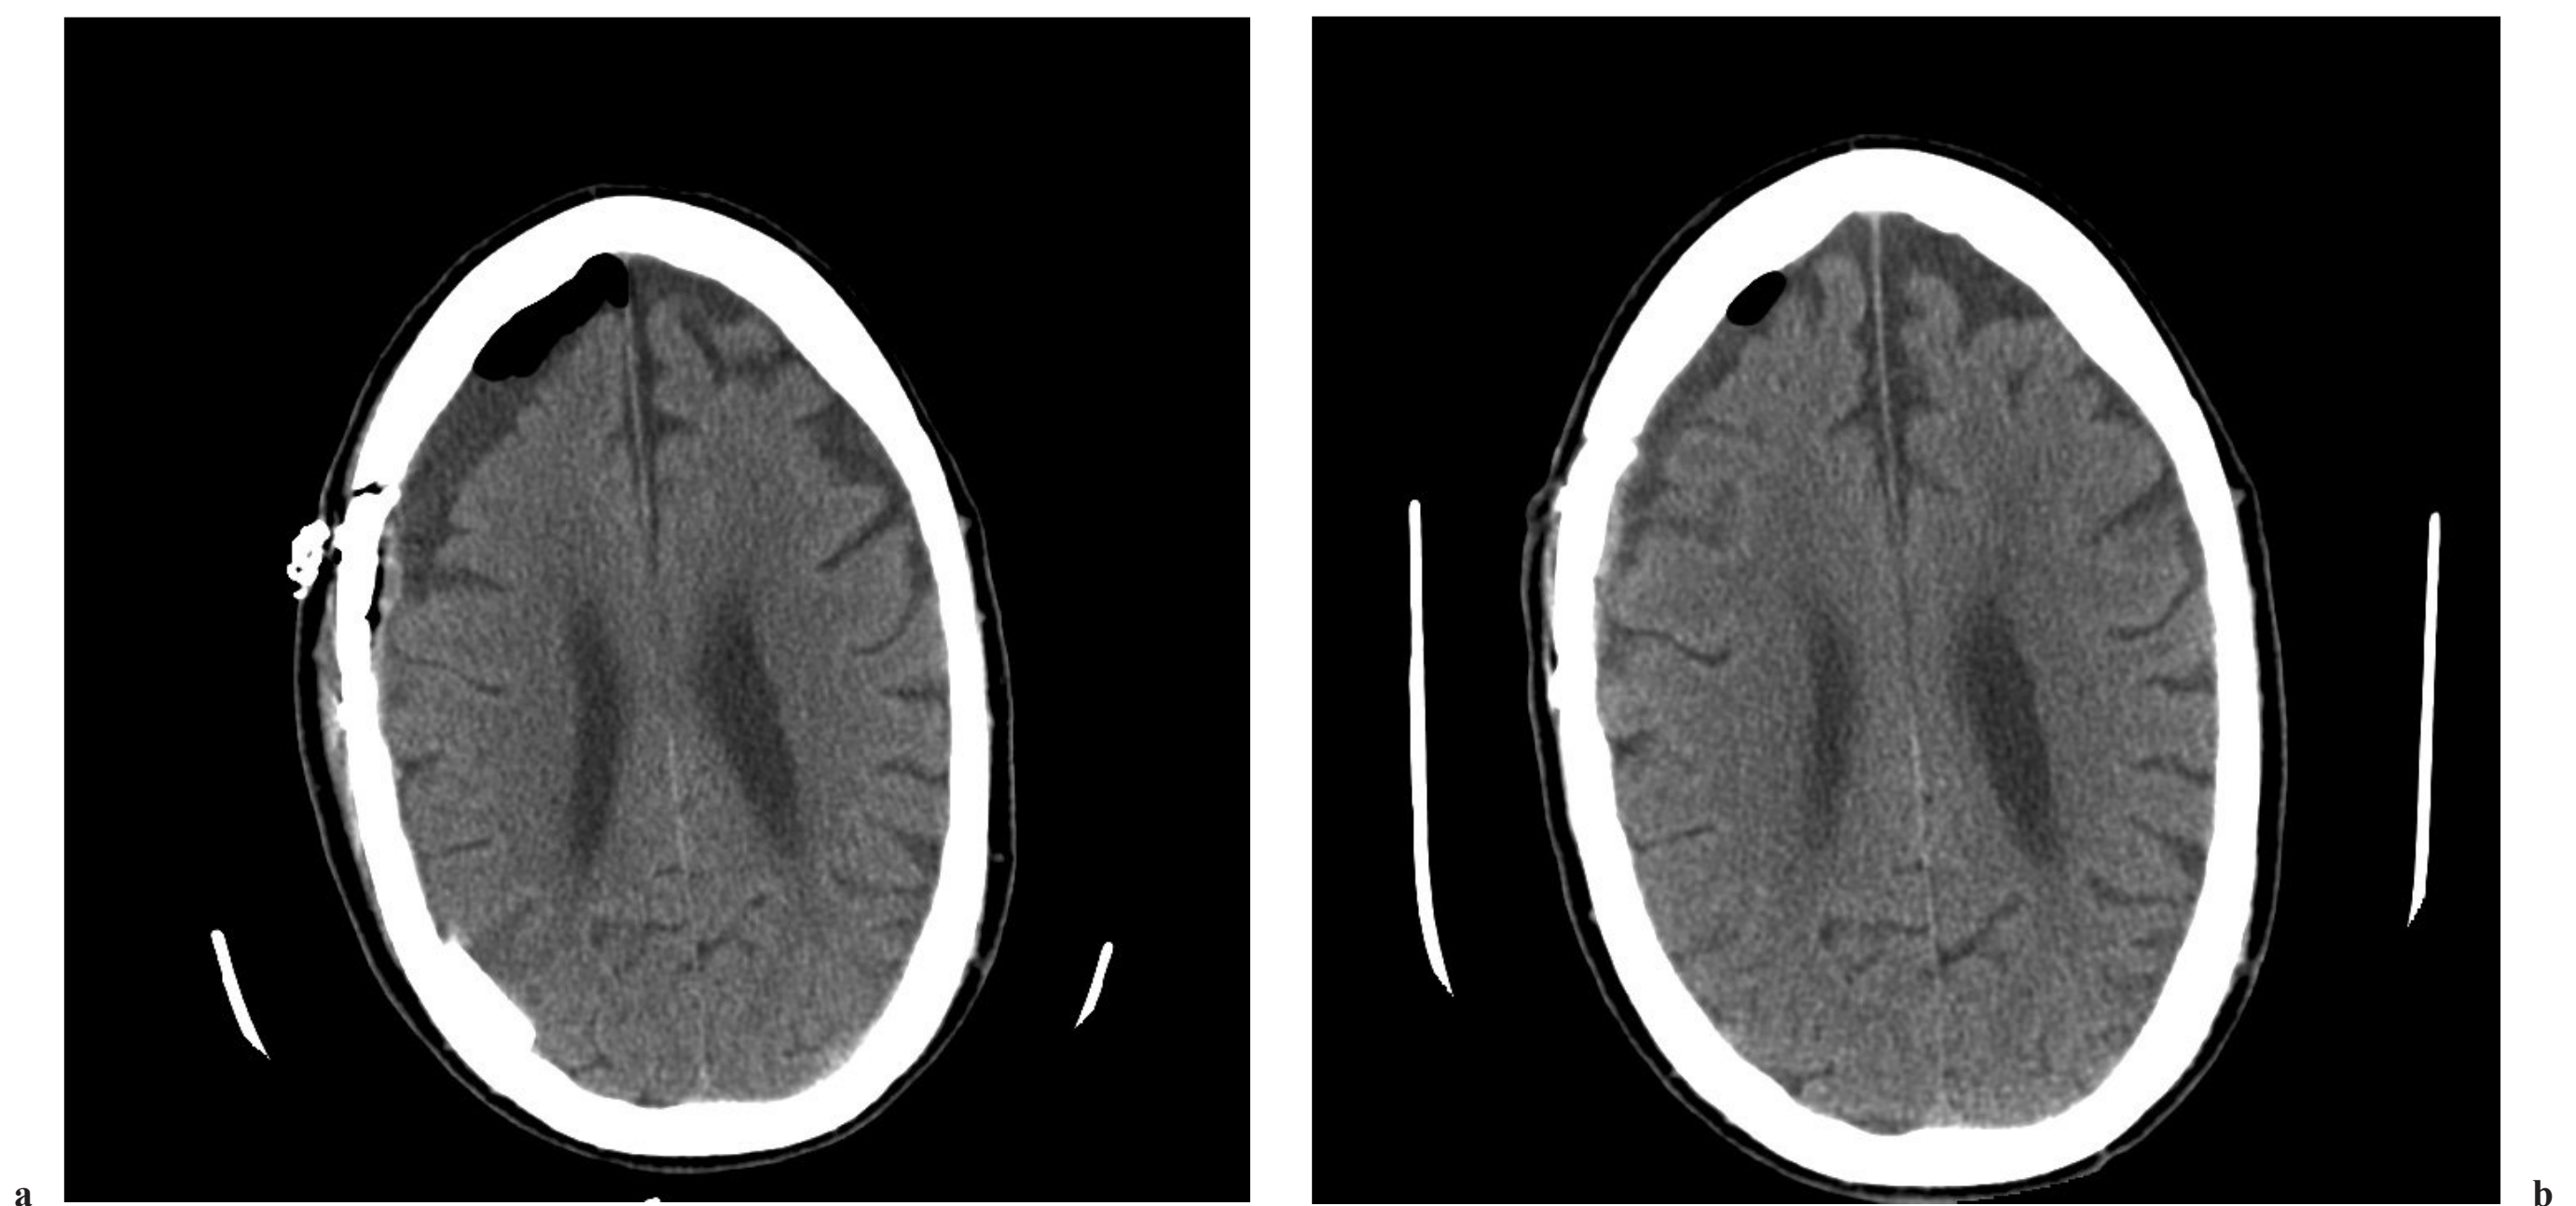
b (a) Postoperative CT of patient in Fig. 2.2 undergoing craniotomy for subdural evacuation. There is a Jackson-Pratt drain in the subdural space and mild pneumocephalus with improvement in mass effect. (b) Delayed scanning after drain removal revealed further decrease in the residual collection.
